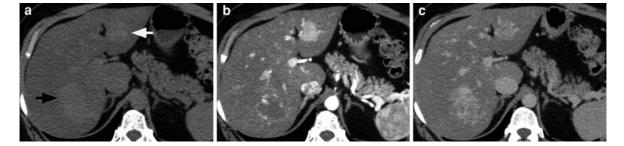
Focal nodular hyperplasia and hepatic hemangioma. a Transverse unenhanced CT image demonstrates two hyperdense lesions, one lesion in the right hepatic lobe (*black arrow*) and the other in the left hepatic lobe (*white arrow*). Note attenuation of the liver is lower than that of the intrahepatic vessels, consistent with hepatic steatosis. b Corresponding contrast-enhanced CT image during hepatic arterial phase shows early, discontinuous, peripheral nodular enhancement of the lesion on the right lobe, suggestive of hepatic hemangioma, and uniform vivid enhancement of the lesion on the left lobe.
